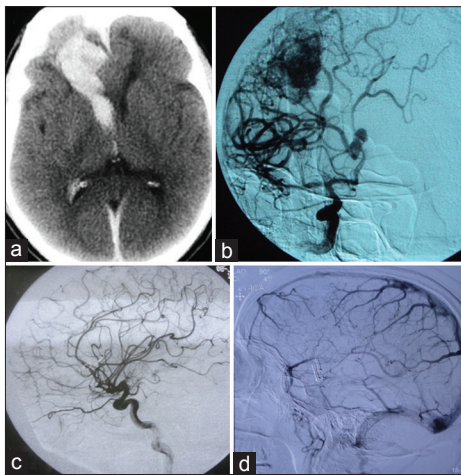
Patient 1 - (a) Axial images of plain CT scan showing hemorrhage in the gyrus rectus, basifrontal region and frontal horn of lateral ventricle, (b) A right internal carotid artery (ICA) digital subtraction angiogram (DSA) showing the posterior frontal arteriovenous malformation (AVM) (Spetzler Martin grade 3; size = 2, venous drainage = 1, eloquence = 0) supplied by anterior and middle cerebral artery with a low flow through the nidus. The aneurysm had ruptured causing the intracerebral hematoma, (c) Follow-up arterial, (d) Venous phase of right ICA DSA lateral view showing the clipped aneurysm with excised AVM
